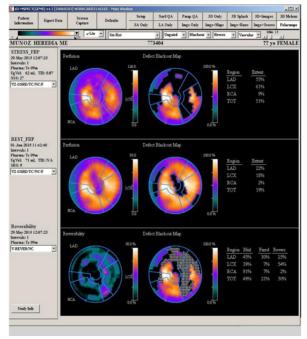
Breast attenuation artifact on gated-SPECT.
